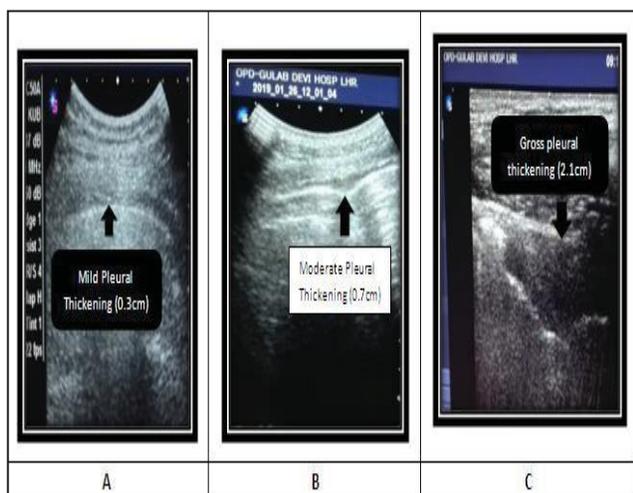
Sonographic grading of pleural thickening.
